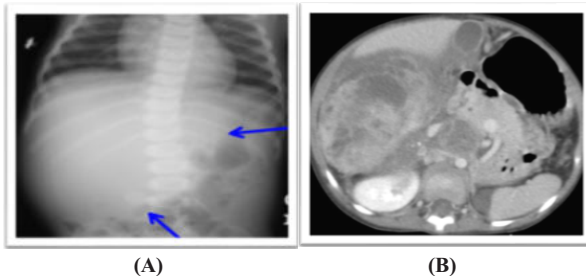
A) X-ray abdomen of 2 years male patient shows large soft tissue mass lesion in right adrenal region. B) CT image of similar patient shows large heterogeneously enhancing soft tissue density lesion with internal necrotic areas in right adrenal region. HPE: Right neuroblastoma.
